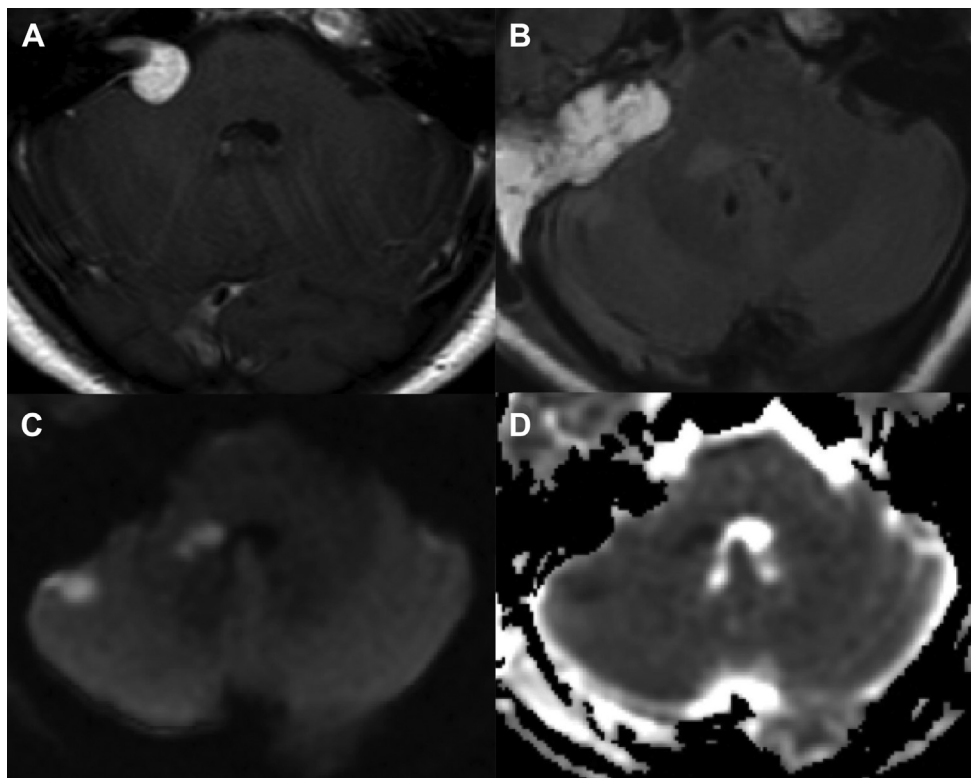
Patient 1. (A) Preoperative T1-weighted post-gadolinium magnetic resonance imaging (MRI) showing a right cerebellopontine angle tumor with intracanalicular extension consistent with vestibular schwannoma. (B) Postoperative fluid-attenuated inversion recovery MRI demonstrating an abnormal increasing signal in the right middle cerebellar peduncle
